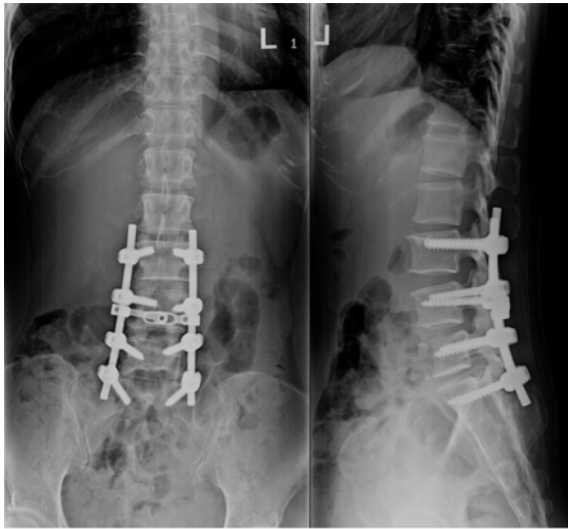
Postoperative plain radiographs at 1-year follow-up.
